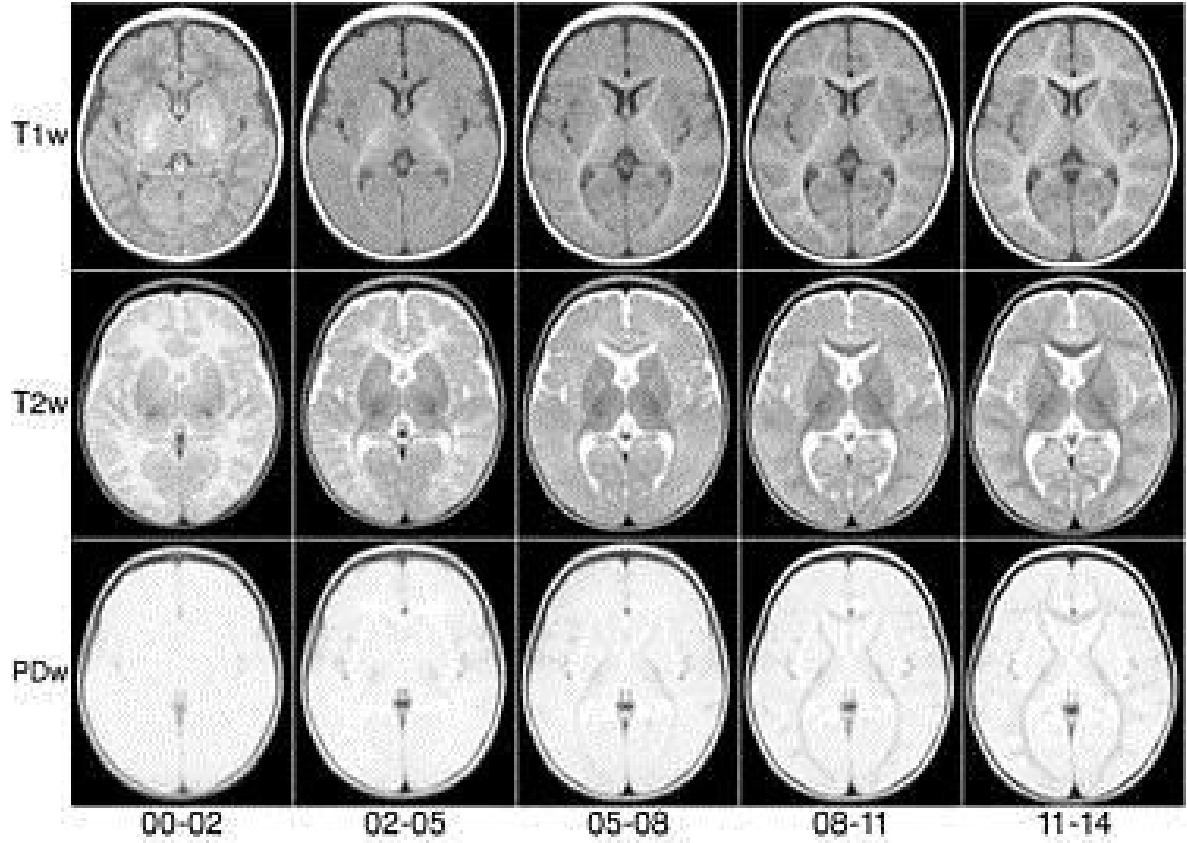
Examples of NIHPD Objective atlases [163]. Upper figures are T1-based intensity-averaged MRI scans, middle figures are T2-based intensity-averaged MRI scans, and lower figures are PD-based intensity-averaged MRI scans. From left to right, atlas for 0-2 years old subjects, 2-5 years old subjects, 5-8 years old subjects, 8-11 years old subjects, and 11-14 years old subjects are shown in this figure.
